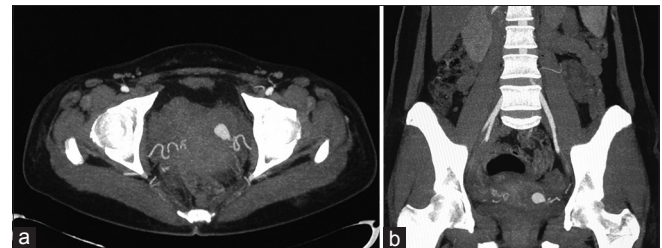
(a) Axial computed tomography angiography maximum intensity projection image shows well-defined oval-shaped highly contrast opacified pseudoaneurysm arising from left uterine artery, (b) reformatted coronal maximum intensity projection-computed tomography angiography image showing the pseudoaneurysm in the same patient
